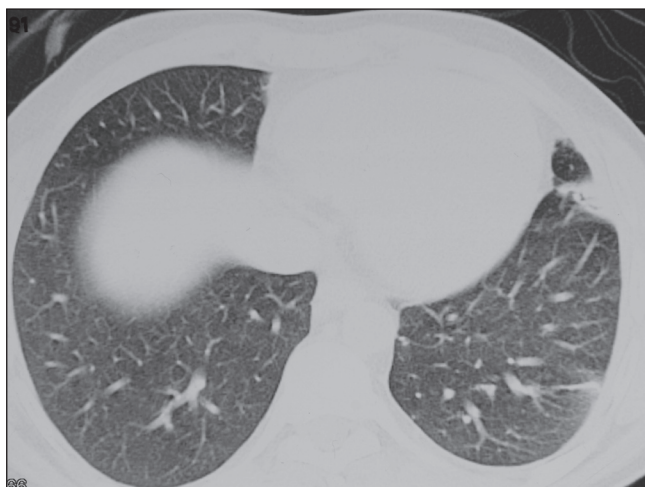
Chest computed tomography scan of an immunocompetent patient (case 3). A small area of consolidation in the inferior segment of lingular (left lung) caused by *Nocardia cyriacigeorgica* is apparent
